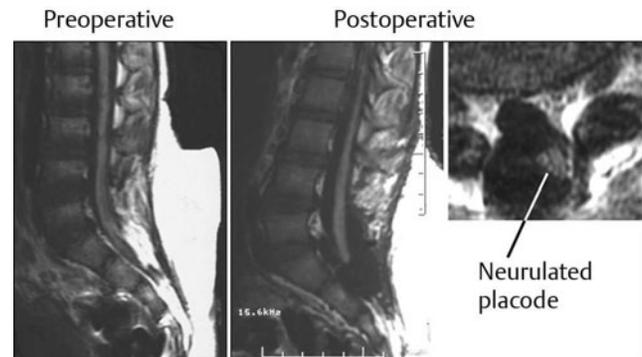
Pre- and postoperative magnetic resonance images of a transitional lipoma with no residual fat after total lipoma resection. Note the neurulated oblong fat-free neural placode within a large dural sac.
